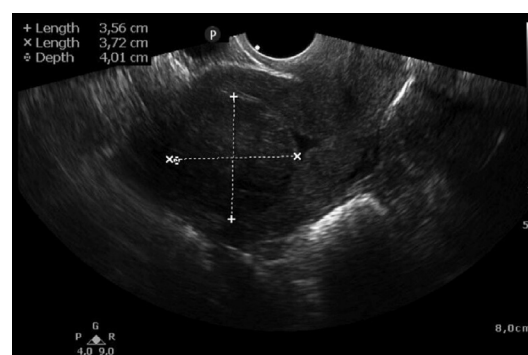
Transvaginal ultrasound showing the FIGO type 2 fibroid before treatment.
